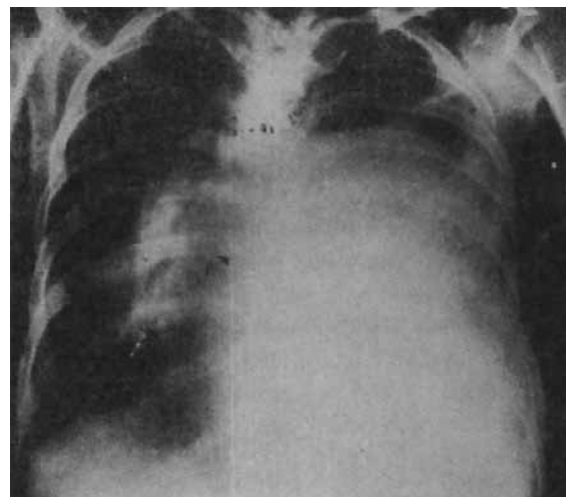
Chest radiograph showing a large left pleural effusion
